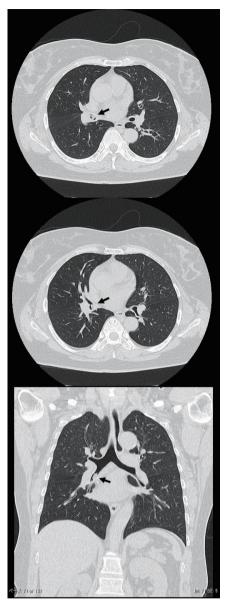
Chest CT confirming the presence of a suspected foreign body (an arrow) in the right truncus intermedius.
